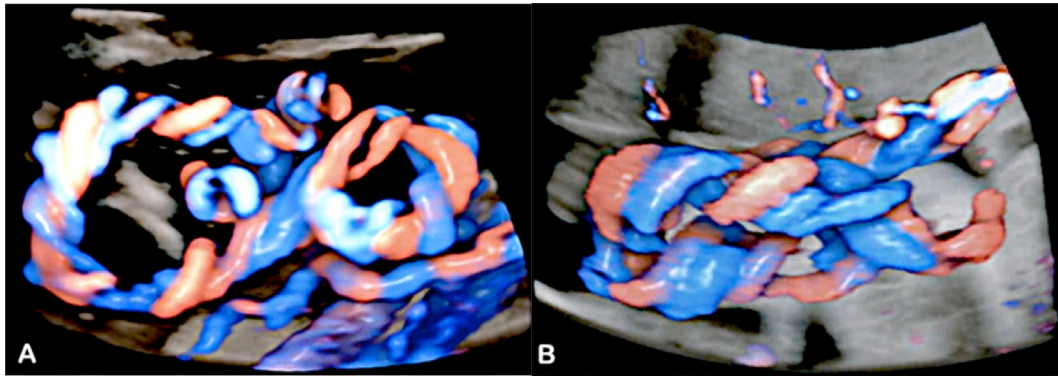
(A) 3D color Doppler ultrasound shows a triple nuchal cord at 37 weeks' gestation [46]. (B) 3D ultrasound using “glass body” rendering mode shows the relation of the vessels with the fetal neck [46]. (C) At Cesarean section, an unreductable triple nuchal cord was confirmed. UV, umbilical vein. *Source:* Courtesy of Juan L. Alcalde, MD.
